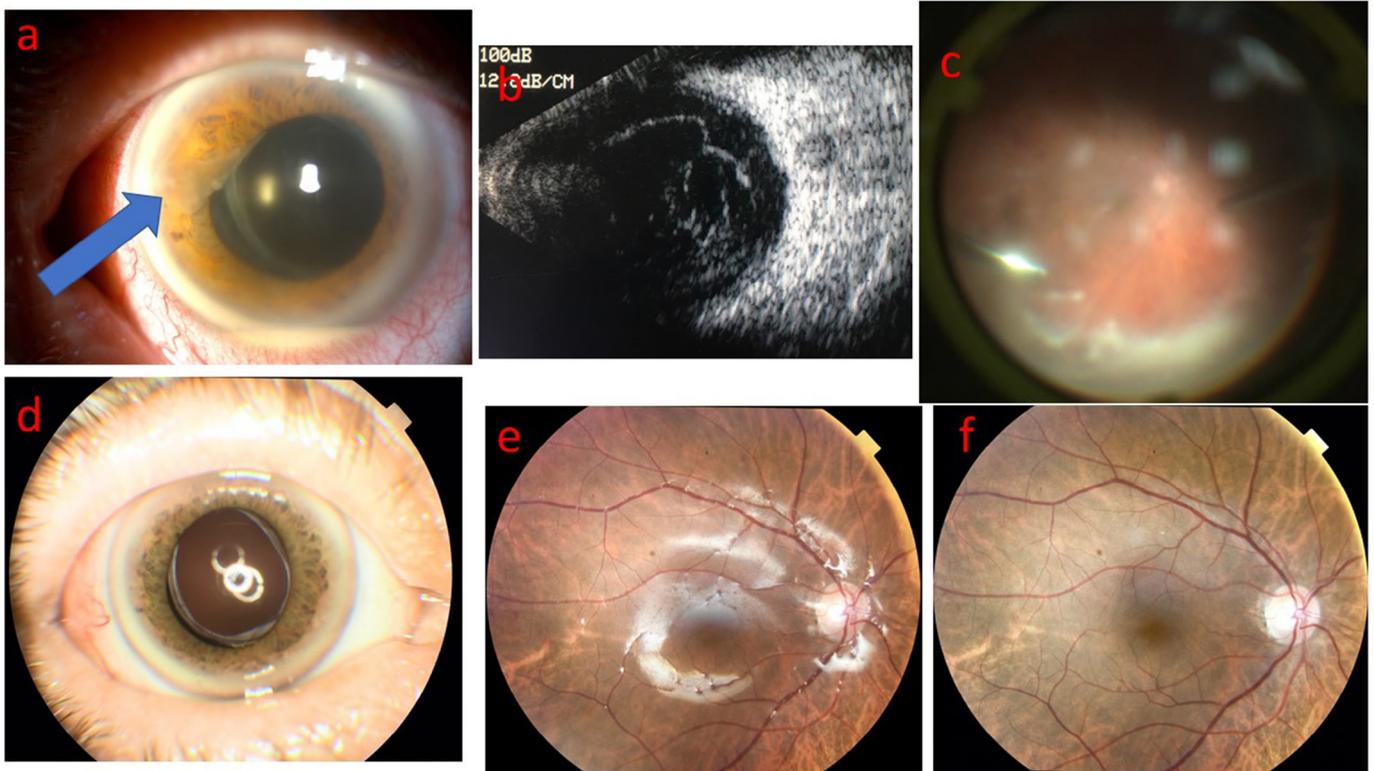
Anterior and posterior segment images of a 78-year-old male patient who applied with the complaint of loss of right vision and pain 6 days after cataract surgery (Case-11). a- In the anterior segment image, hypopyon and fibrin are indicated by the blue arrow. Visual acuity was hand motions b- There are irregular hyperechoic areas in the ultrasonography of the right eye. c- In the intraoperative image, lower vitreous infiltration areas are seen. d- The anterior segment is normal 2 months after PPV. e- Retinal was attached under silicone in the 2nd month after PPV. f- The retina is normal in the 3rd month after silicone removal. Right vision 0.5 decimal.
